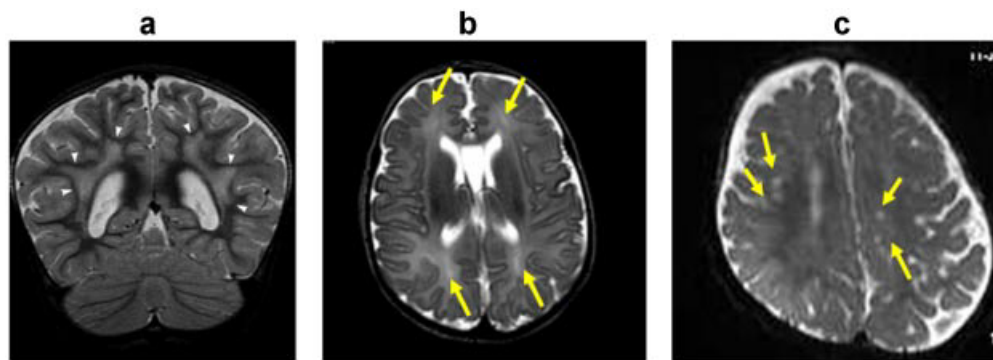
Brain magnetic resonance imaging performed at age 14 months in a patient with 49, XXXXY. There is ventriculomegaly and a slightly thin body of the corpus callosum, which are otherwise nonspecific findings. In coronal T2-weighted images (a), there are extensive patchy and confluent areas of abnormal high signal intensity in the periventricular and deep white matter. This affects primarily the parietal and frontal lobes (a and b). The subcortical U-fibers are spared. In a second patient (c) there are more punctuate lesions (arrows).
